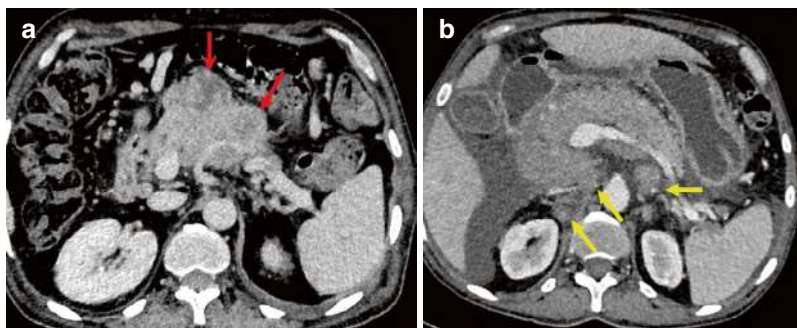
Pancreatic lymphoma on CT in two different patients. (a) A 57-year-old male with PPL with multifocal hypodense masses (red arrows) encasing splenic artery without narrowing with the absence of other systemic involvement and mild peripancreatic lymphadenopathy.
